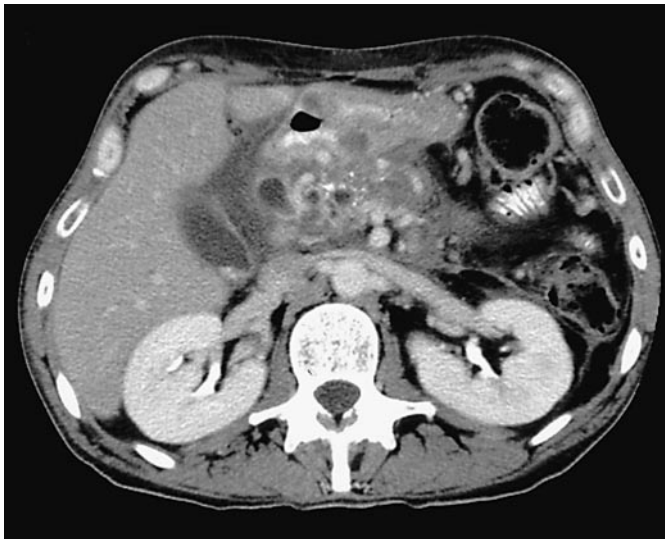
CT of the pancreatic head. A large ill-defined lesion is seen with cystic and solid portions, some calcifications were visualized. Dilatations of the bile and pancreatic ducts were present: chronic inflammatory pseudotumor of the pancreatic head.
